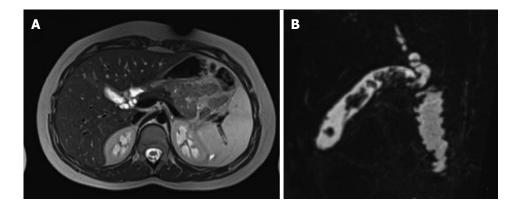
T2-weighted magnetic resonance imaging images confirming the irregular and diffuse thickening of gallbladder walls, more prominent in the body and in the fundus, suggestive of diffuse adenomyomatosis of the gallbladder (A and B). Nodular images with intraluminal protrusion were localized in the fundus and in the body of the gallbladder.
